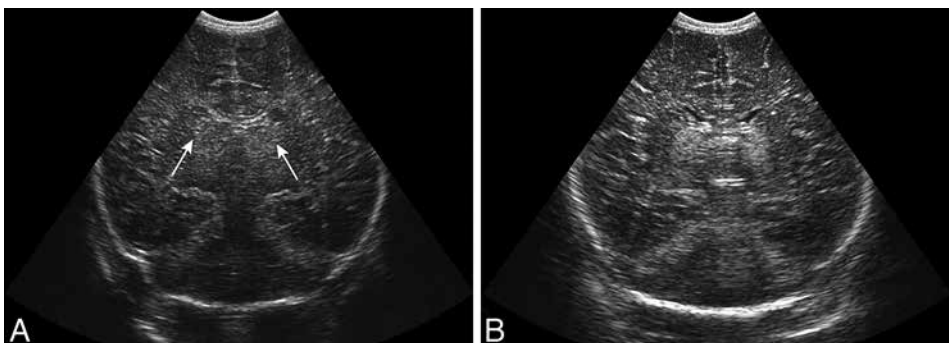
Coronal ultrasound scans in a full-term neonate with severe hypoxic-ischemic encephalopathy. (A) Scan frequency of 7.5 MHz, showing subtle echogenicity of the thalami (arrows). (B) Scan frequency of 5 MHz, the echogenicity is now more obvious.
